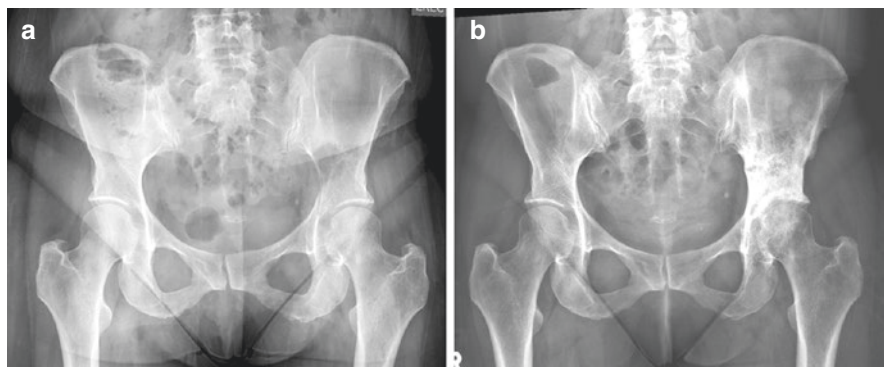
Initial (a) radiograph of a 44-year-old woman who presented with a destructive lesion and pathologic fracture of the left supraacetabular region. Three-year follow-up (b) radiograph demonstrating reconstitution of the bone with bisphosphonates and radiation therapy alone
